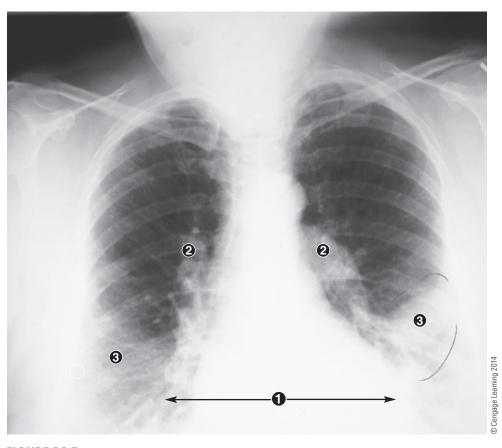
Chest radiograph shows cardiomegaly (1); pulmonary vascular congestion (2); bilateral infiltrates (3).
